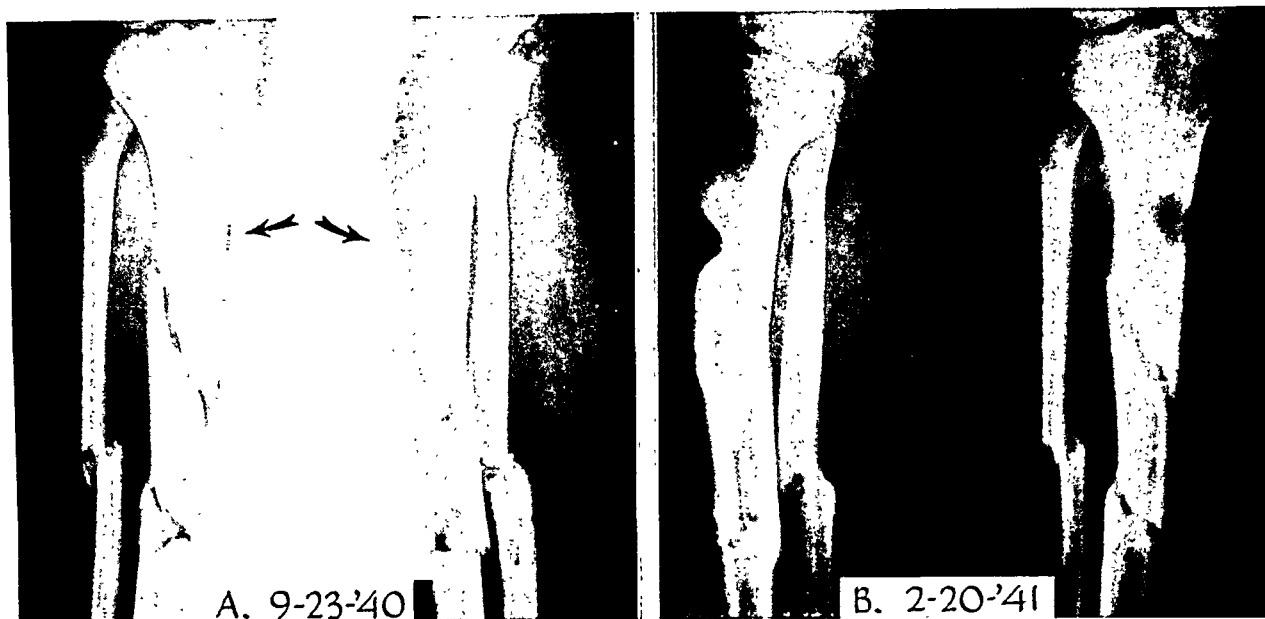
Case I. Steinman pins were put through upper fragment of tibia and calcaneus. Pins were in position for forty-two days. *A* shows the "ring" sequestrum with the density about the pin hole which is in turn surrounded by a zone of rarefaction. *B*, roentgenogram on February 20, 1941, showing some periosteal proliferation and filling in of new bone. Note also the callus formation about the fracture sites. Patient was last seen on April 10, 1941, at which time he was walking without any difficulty. Unfortunately a roentgenogram was not made at this time.
